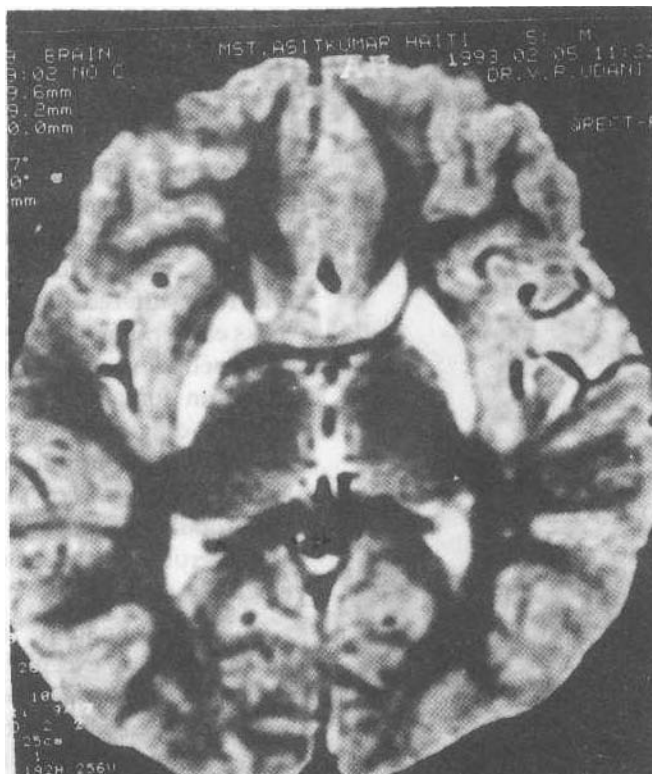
MRI (T2 weighted image) showing increased signal intensity in caudate and putamen bilaterally.
